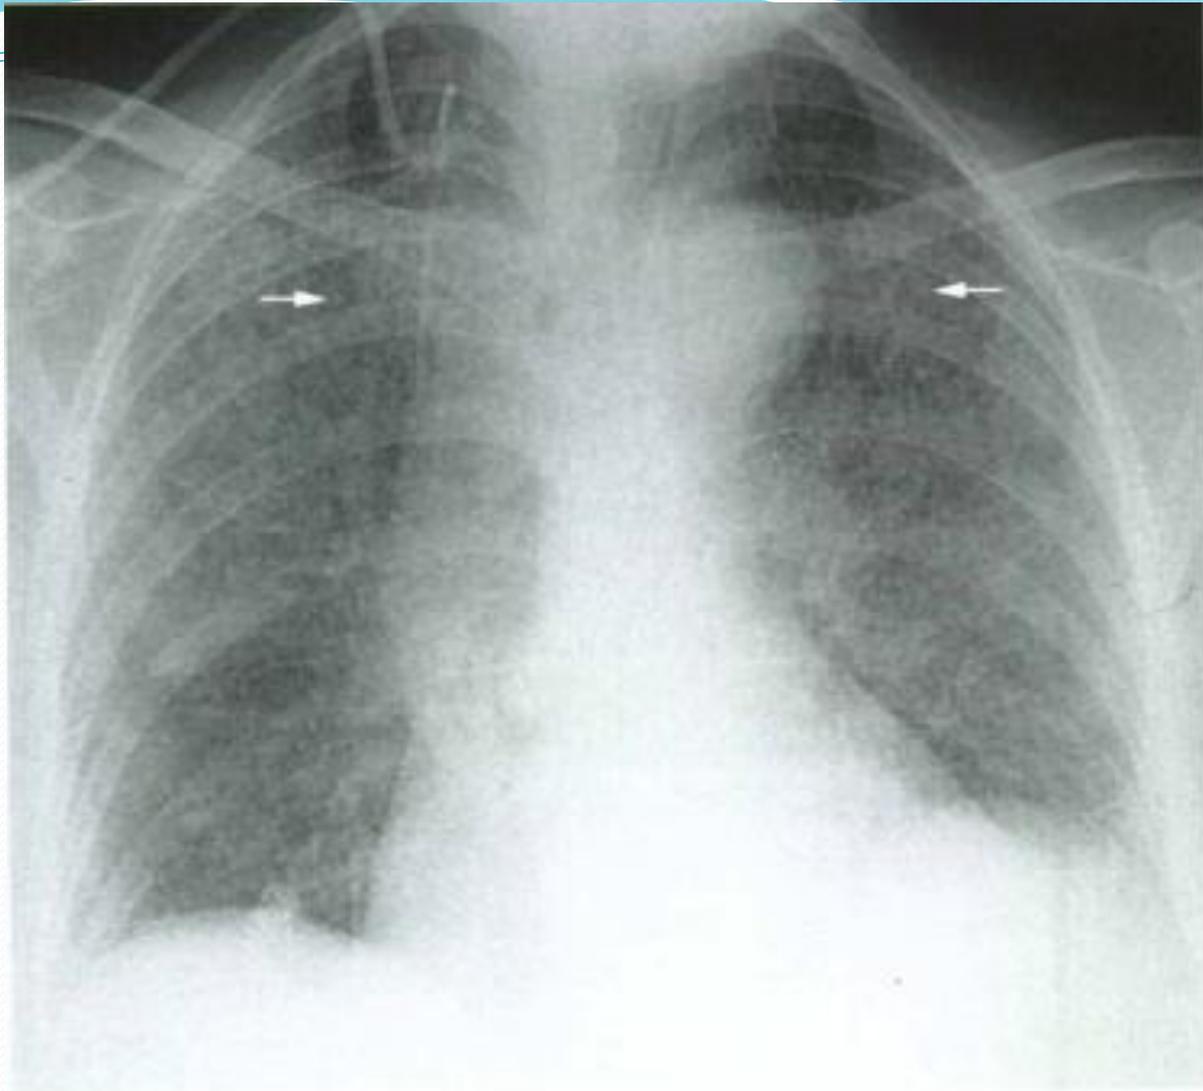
Miliary spread of *Mycobacterium tuberculosis* infection. Frontal chest radiograph shows innumerable, bilateral, diffusely distributed small nodules representing miliary (hematogenous) spread of MTB infection.
